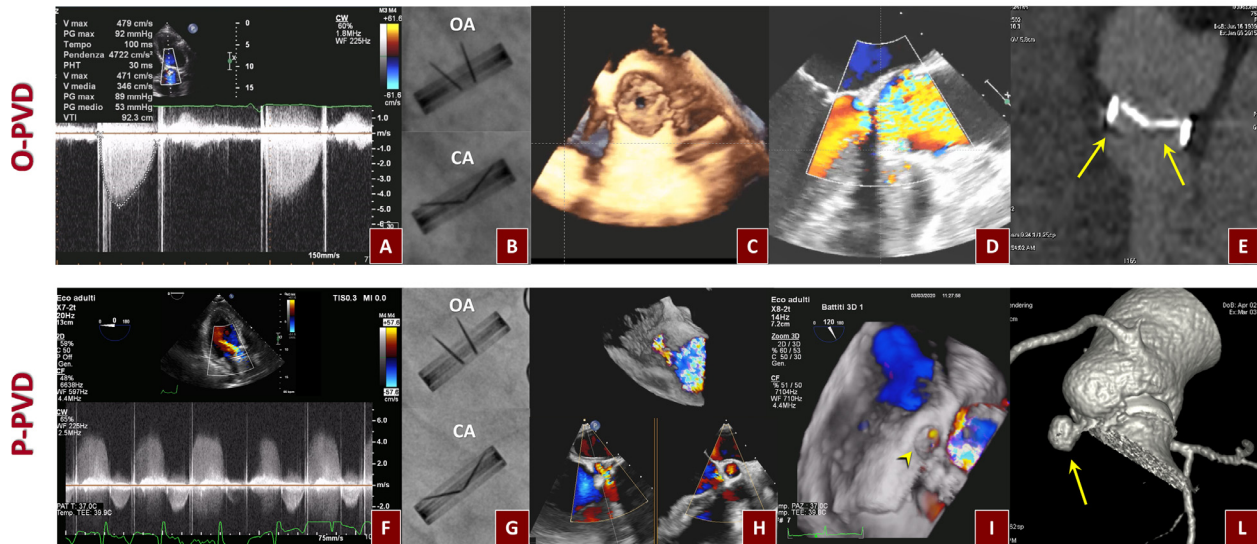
Examples of obstructive and paraprothetic aortic valve dysfunction. Top. O-PVD: (A) high transprosthetic gradient documented with continuous wave Doppler by TTE, (B) abnormal opening and closing angle at fluoroscopy, (C) subaortic pannus at 3D TEE, (D) flow acceleration due to the subvalvular tissue at the level of the ring seen by color TEE, (E) pannus ingrowth (yellow arrows) as hypodense subprosthetic tissue on the ventricular side of the prosthesis detected by CT. Bottom. P-PVD: (F) holodiastolic regurgitation at continuous wave Doppler TTE, (G) normal leaflet motion at fluoroscopy, (H-I) pseudoaneurysm with paraprothetic regurgitation assessed by 2D and 3D color TEE (yellow arrowhead), (L) pseudoaneurysm reconstructed by CT (color version of figure is available online.).
